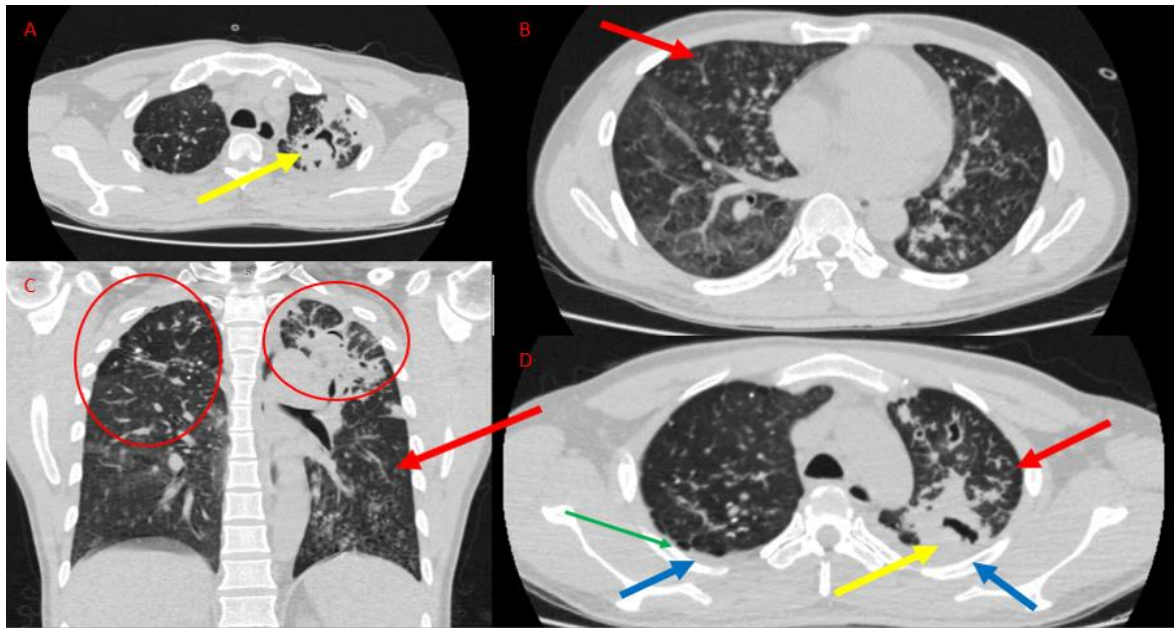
Chest Computed Tomography: A Depiction of Pulmonary Tuberculosis with Aspergilloma.
